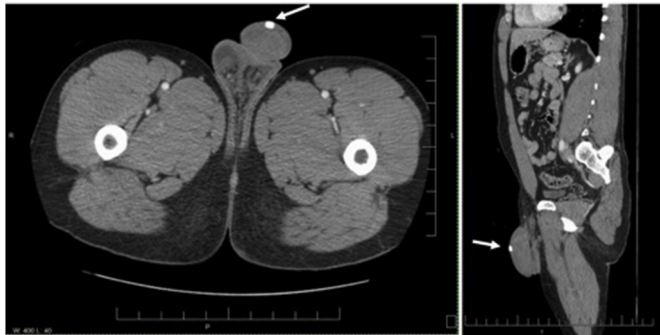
CT abdomen and pelvis depicting the dorsal subcutaneous penile foreign body (white arrow).
